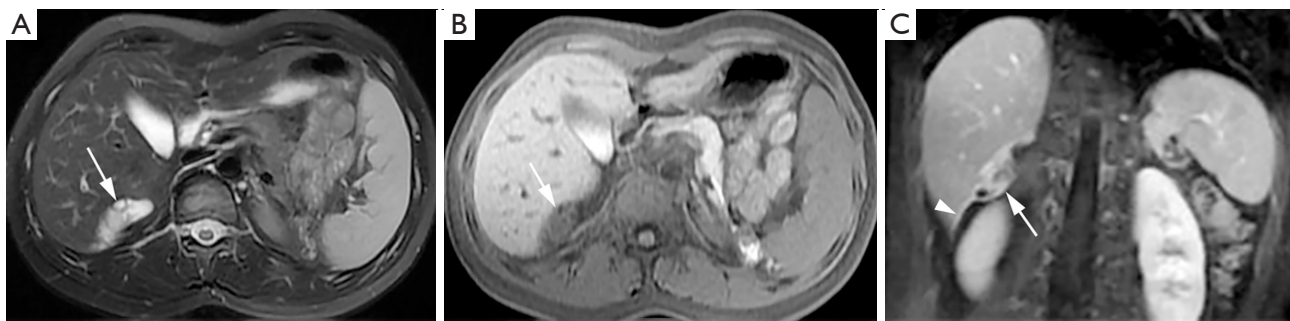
Preoperative upper abdominal MR imaging. (A) Axial fat-suppressed T2-weighted imaging revealed multiple cysts in the oval mass of the hepatorenal space with heterogeneous hyperintensity (arrow). (B) Axial T1-weighted imaging revealed an oval mass with unclear margins adjacent to the liver with mild hypointensity (arrow). (C) Coronal postcontrast fat-suppressed T1-weighted image showed a solid content of the mass with obvious enhancement (arrow) and a cord-like structure connected to the mass (arrowhead). MR, magnetic resonance.
